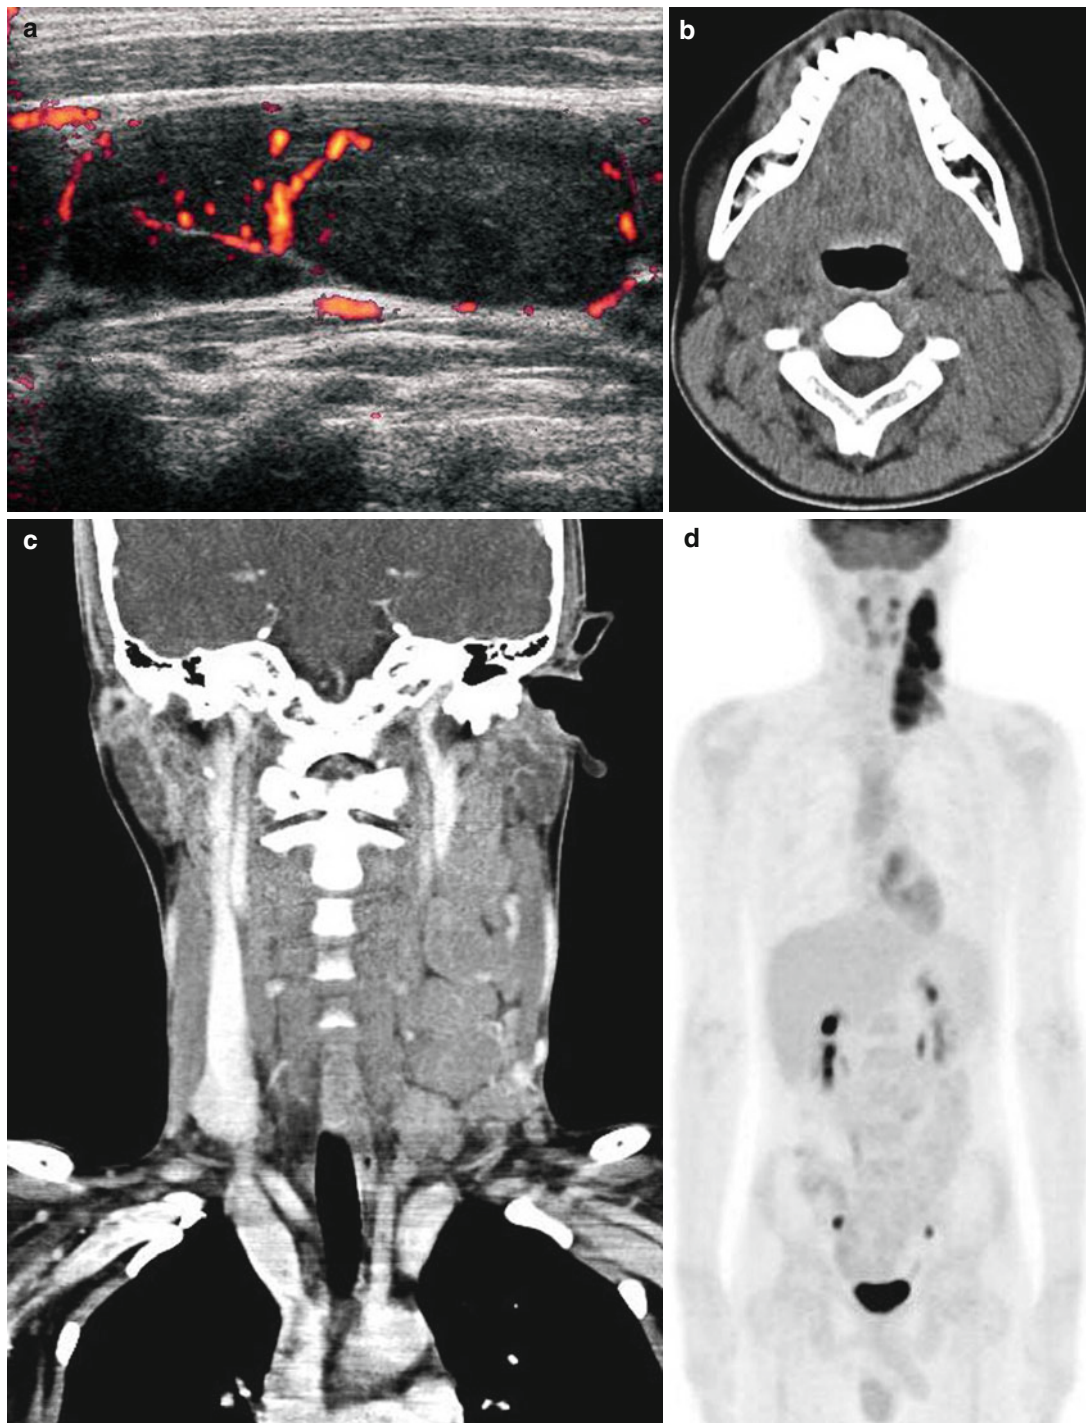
HL in a 14-year-old boy. (a) US shows an elliptical shaped, homogeneous but large cervical lymphadenopathy with eccentrically displaced hilum and peripheral vascularity. (b) Noncontrast CT scan shows multiple large homogeneous cervical lymphadenopathies. (c) Contrast-enhanced coronal reformatted CT scan shows
